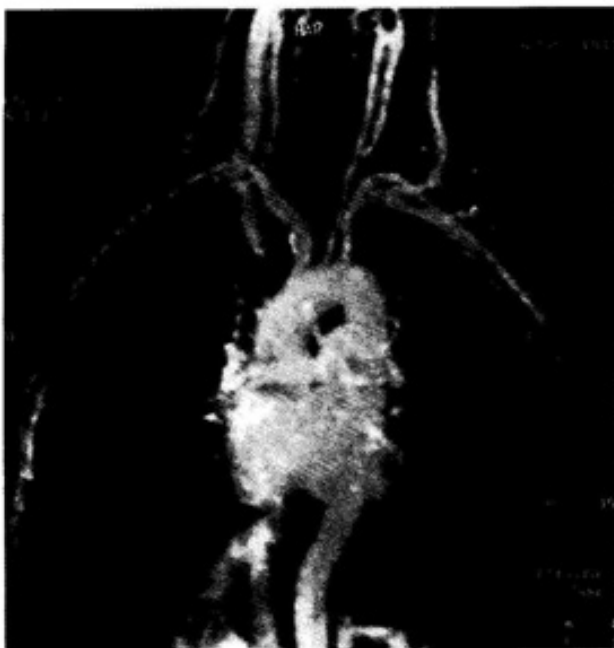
Magnetic resonance imaging and angiogram revealed the obstruction of the vena cava superior at the level of innominate vein.
